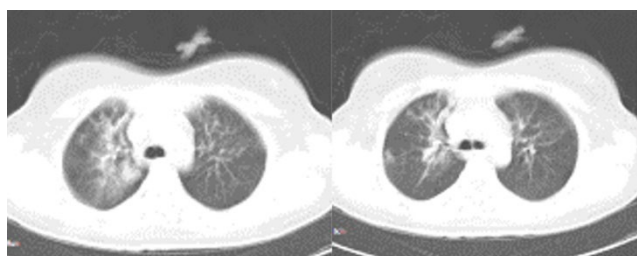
Chest CT scan shows peribronchovascular consolidation and ground glass opacities, particularly in the right upper lobe
